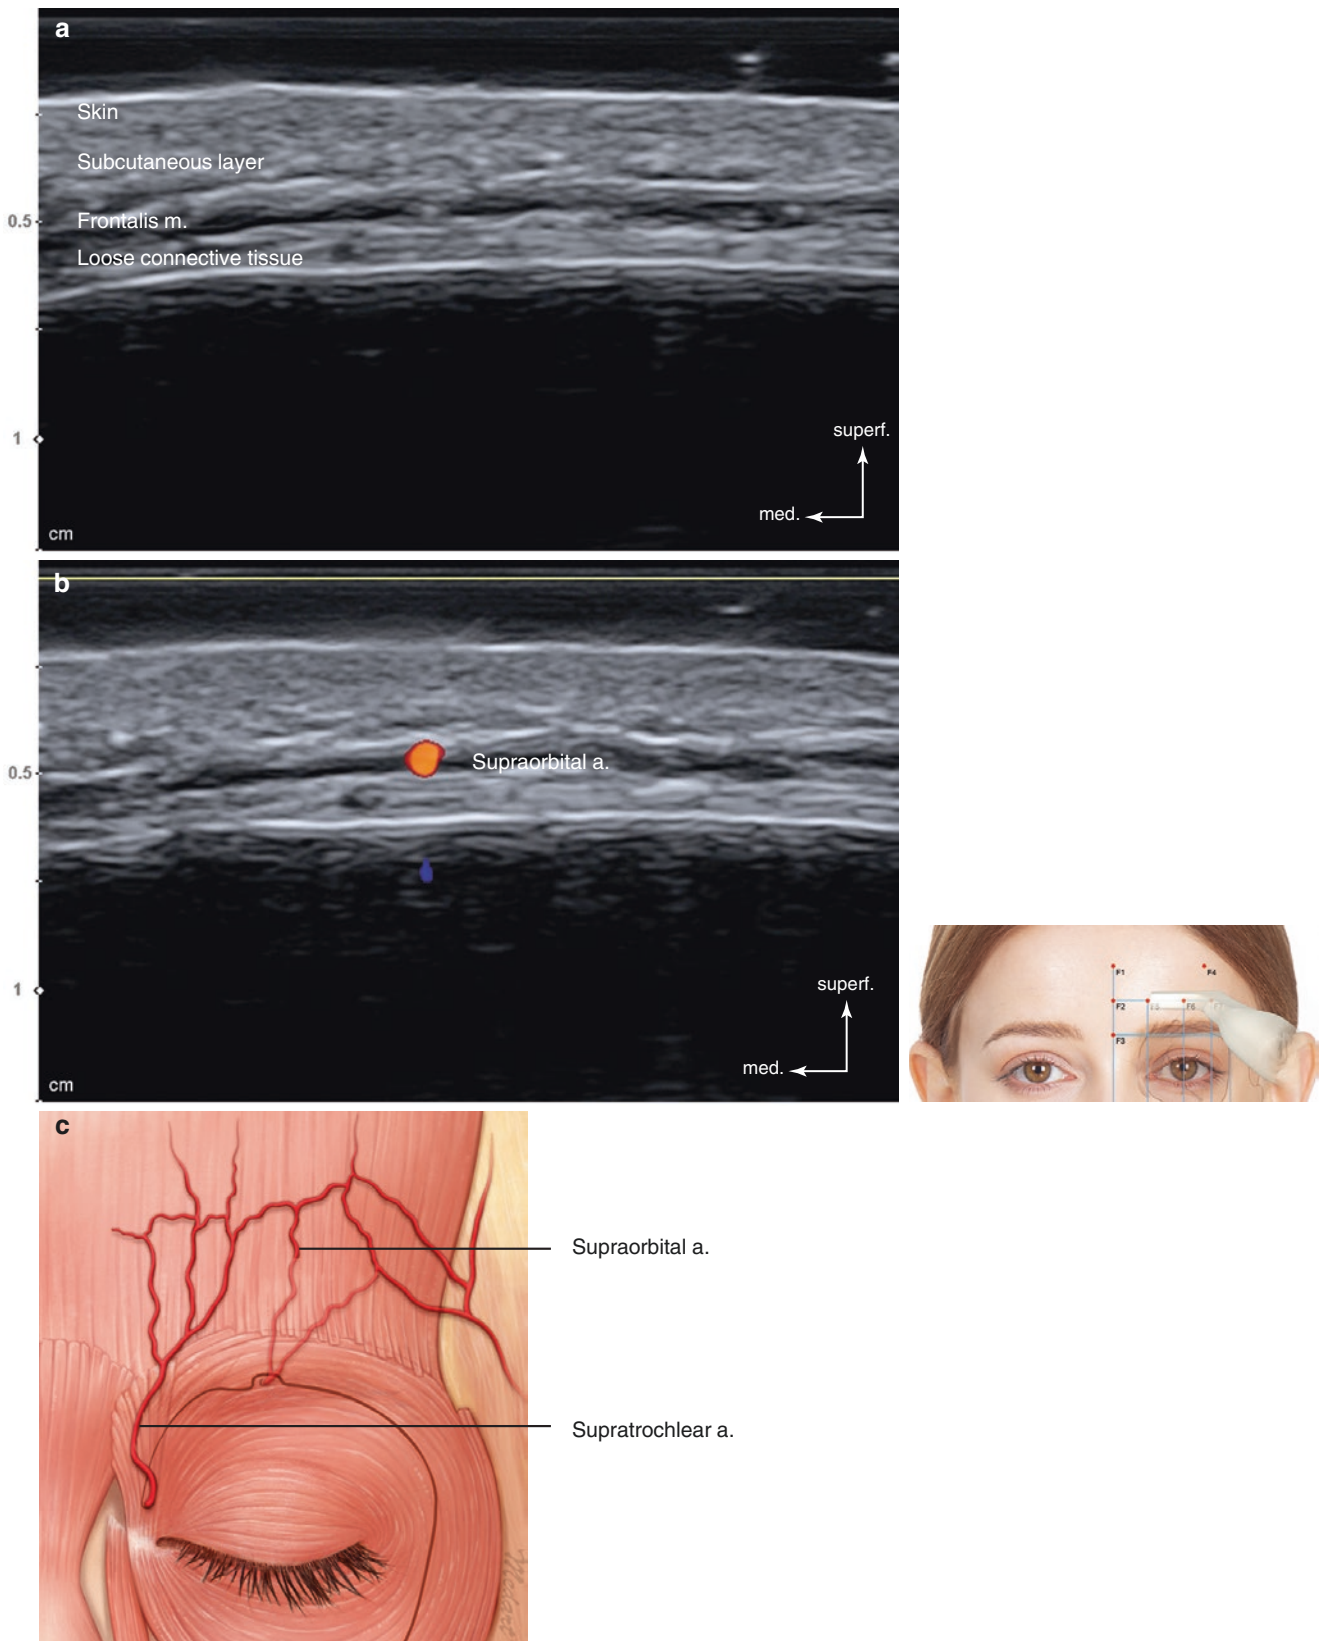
Ultrasonography of the intersection point of TL1 and PL2 (F6). (a) B mode (transverse view, 15 MHz by linear transducer), (b) Doppler mode (transverse view, 15 MHz by linear transducer), and (c) arterial distribution on the forehead. (Published with kind permission of © Hee-Jin Kim and Kwan-Hyun Youn 2020. All Rights Reserved)
